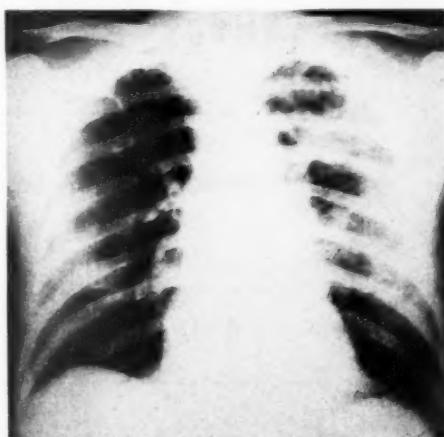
Chest X-ray taken on 4.12.57, showing consolidation especially in the left lung.
